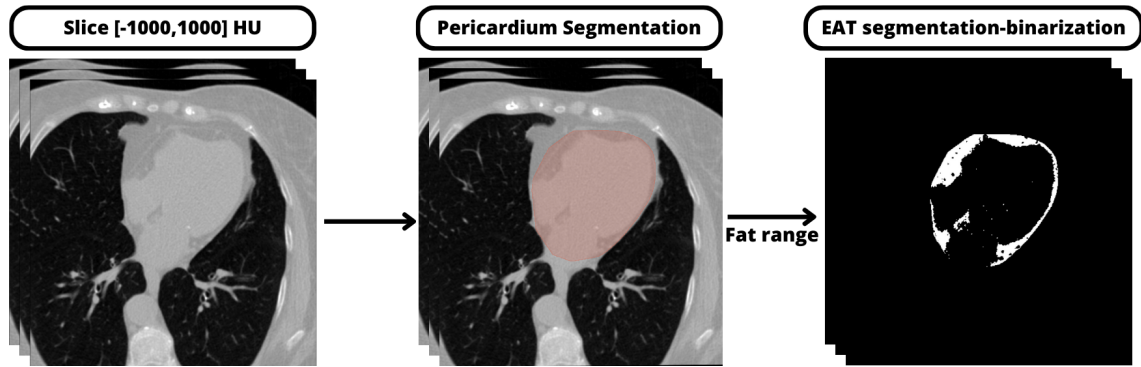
Process of segmenting the EAT from CT scans.
